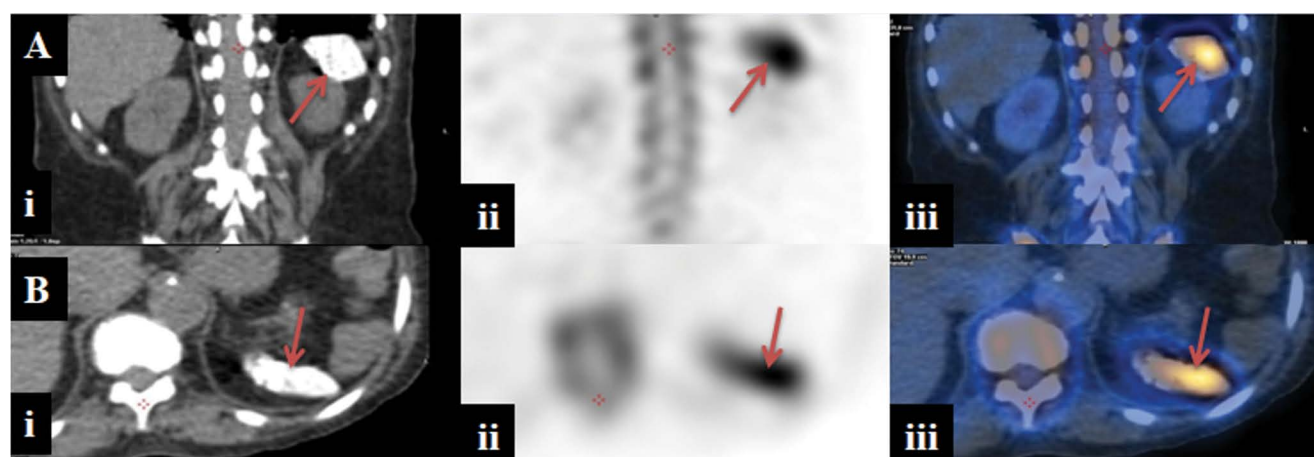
(A) Coronal images; (B) axial images; (i) computed tomography (CT); (ii) single photon emission computed tomography (SPECT); (iii) (SPECT/CT). Single photon emission computed tomography/computed tomography (SPECT/CT) exam confirms the radiotracer activity seen in bone scintigraphy in the left upper abdomen area showing splenic uptake (arrows)
